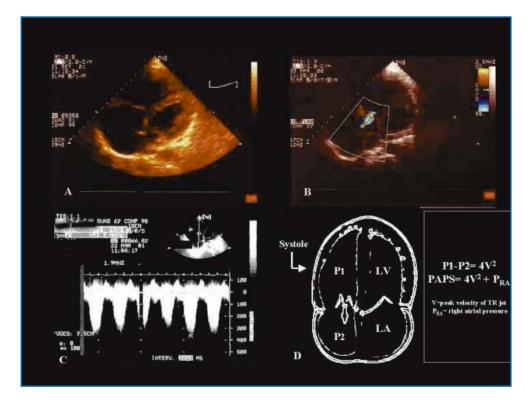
Transthoracic ecochardiographic findings in HIV-associated pulmonary hypertension. The pulmonary arterial systolic pressure can be estimated by measuring the Doppler flow through the tricuspid valve according to Bernulli's modified formula: $P=4V^2$ (where *P* is pressure gradient and *V* is peak retrograde velocity). The right atrial pressure (P_{RA}) is nominally estimated at 10 mmHg
